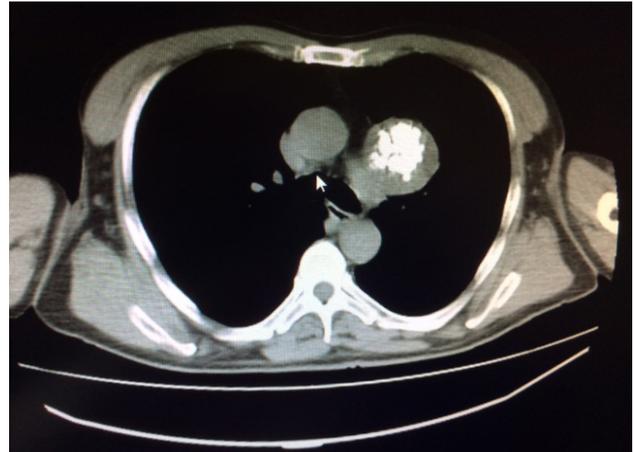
The computed tomography scan of the thorax shows a 5.4x5.2 cm well-circumscribed mass with popcorn calcification near left pulmonary artery and proximal descending aorta in the anterior mediastinum.
